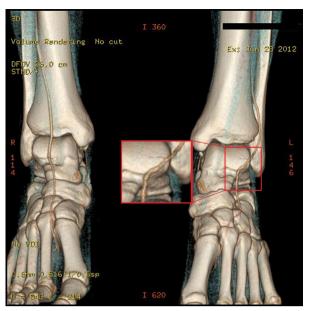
Angio CT — atypical localization of tibial anterior artery and dorsalis pedis artery aneurysm
